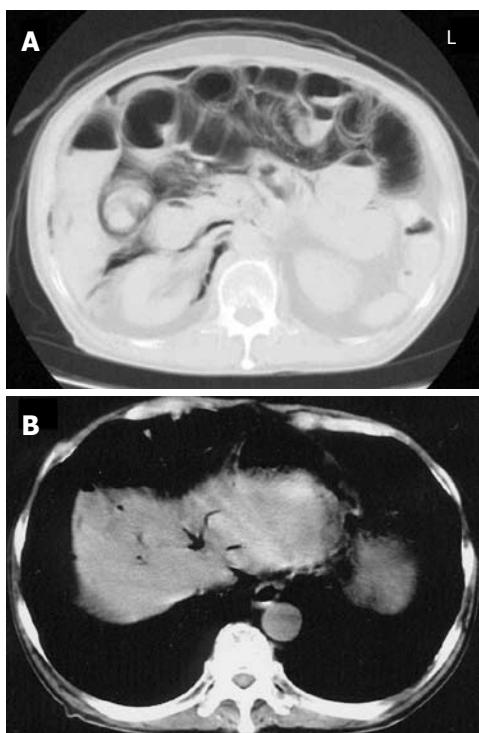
Abdominal CT scan showing excessive intraluminal gases in the entire small intestine and free air in the retroperitoneal space (A), and free air in the falciform ligament (B).
